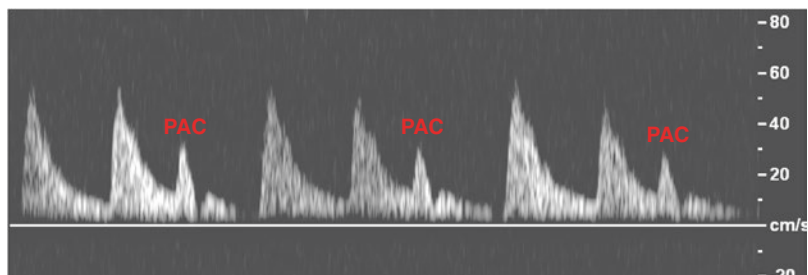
Pulse Doppler of the aortic outflow showing PACs in trigeminy. A PAC occurs every third beat
